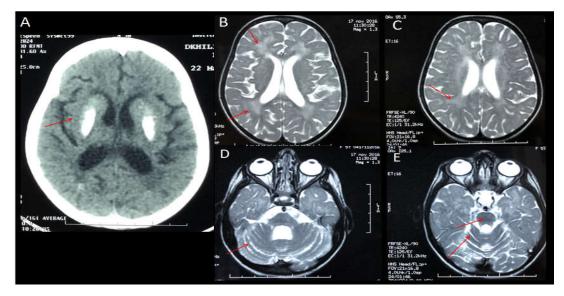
3D Neuro-imaging A: Brain CT scan showing lenticular calcifications B,C:T2-weighted axial slice MRI images showing a periventricular white matter hypersignal and a ponto cerebellar atrophy (D,E)
